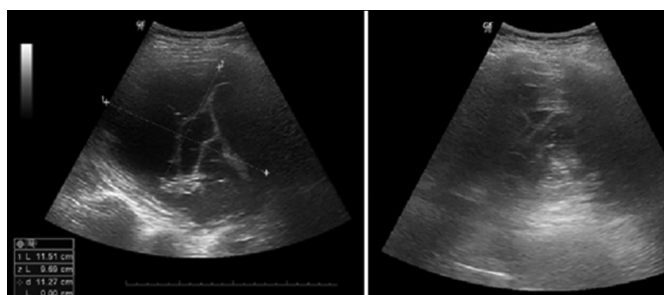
Sonographic appearance of the cyst during (A) and after (B) cyst aspiration.
